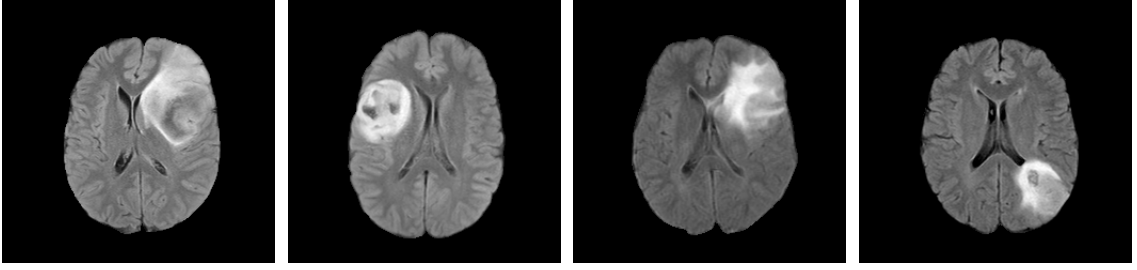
Examples of different DLGG appearances on FLAIR T2 MRIs.*
